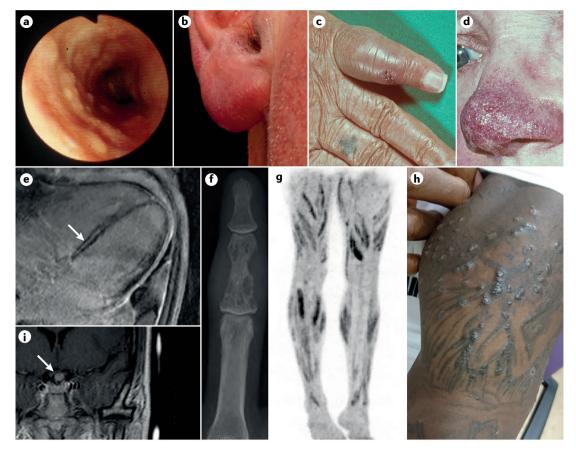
Extrapulmonary manifestations of sarcoidosis. a | Endobronchial cobblestones (a nodular appearance of the tracheal wall mucosa). b | Diffuse reddish swelling of the earlobe due to skin localization of sarcoidosis granulomas. c | Sarcoid dactylitis (classical Perthes–Jüngling disease associated with sarcoidosis) causing cystic lesions in the hand bones. d | Lupus pernio (a chronic hardened red lesion of the skin). e | Cardiac sarcoidosis with midmyocardial delayed enhancement (arrow) on MRI. f | Radiography scan of the finger of a patient with sarcoid dactylitis. g | Skeletal muscle involvement, visualized on fluorodeoxyglucose-PET scan of the lower limbs. h | Sarcoidal reaction with nodular thickening of the skin at the site of tattooing in a patient with pulmonary sarcoidosis. i | MRI scan showing a neurosarcoidosis lesion (arrow) to the left and caudally of the optic chiasma.
